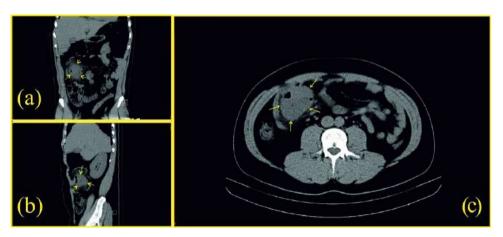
Preoperative computed tomography (CT) Scan: (a) native axial series, (b) native coronal, and (c) sagittal series.
